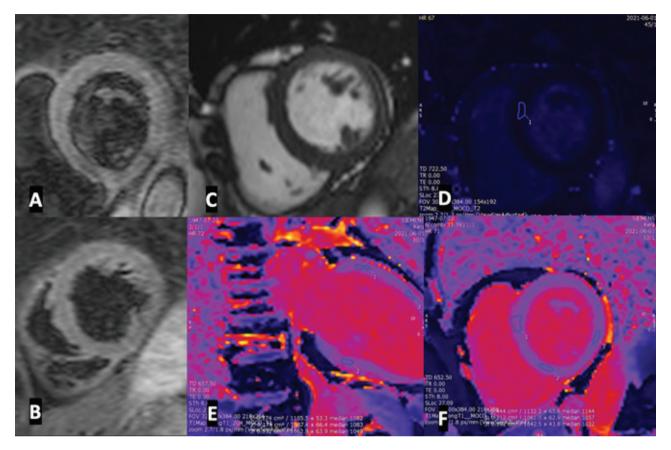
73 years old woman who developed DCM after receiving chemotherapy due to operated breast cancer. SA STIR images (A, B) Show subtle edema at the basal intraventricular septum. Short Axis (C) Cine MRI (SSFP) shows LV dilatation (Ejection Fraction 55%). T1 MAPPING (E, F) and T2 MAPPING (D) images visualize increased values indicative of replacement fibrosis and edema.
